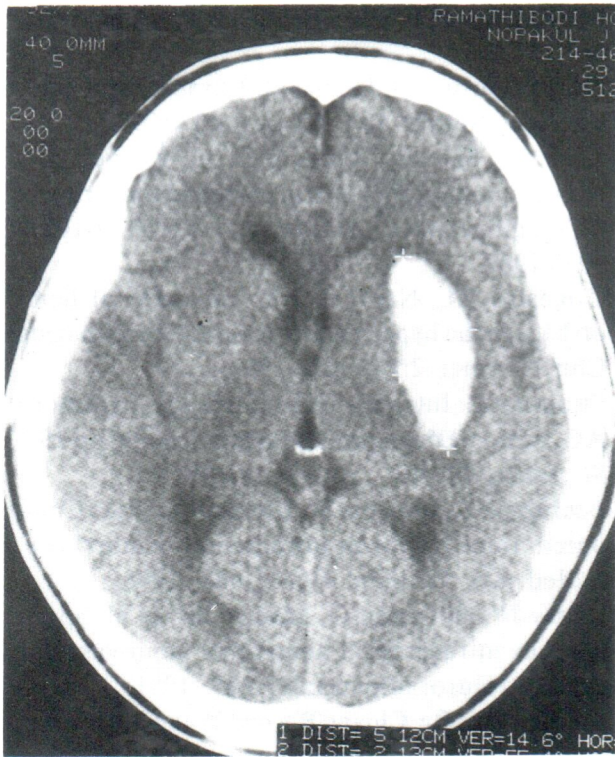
CT shows hematoma in the location of left putamen-external capsule
